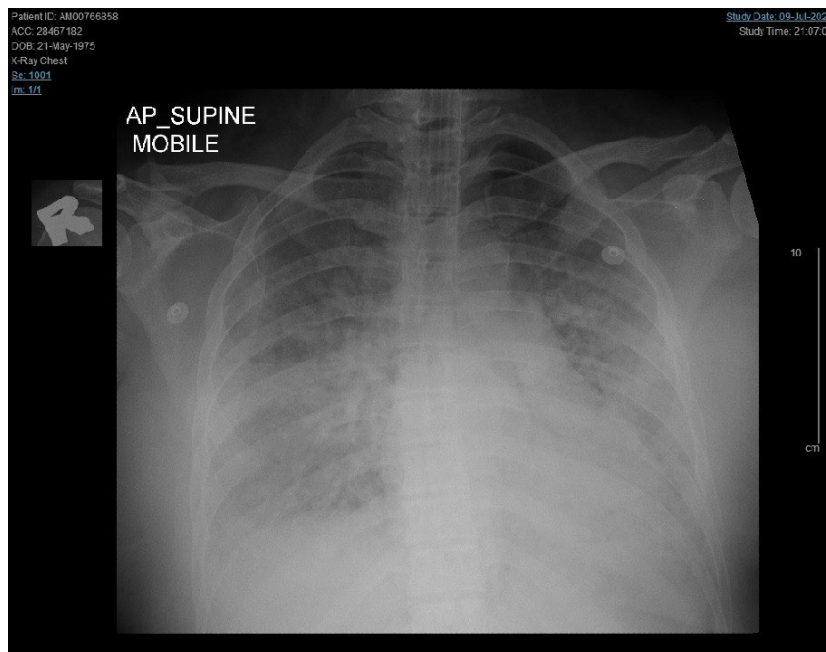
Plain anterior posterior chest radiography demonstrating radiolucent areas bilaterally (Red arrow) within the region of the mediastinum (left > right) with double bronchial signs. There was soft tissue gas at the neck region.
